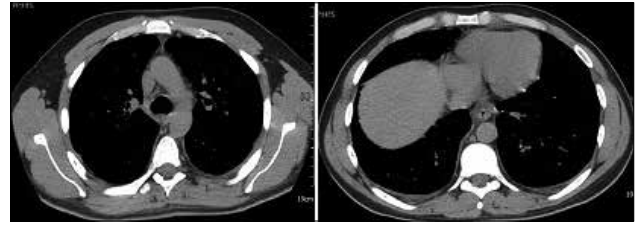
Thorax computed tomography: bilateral minimal effusion, no lymphadenomegaly
